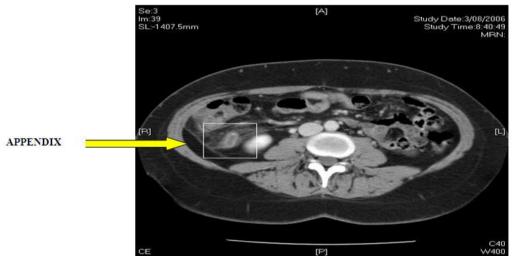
Appendix on magnetic resonance imaging
